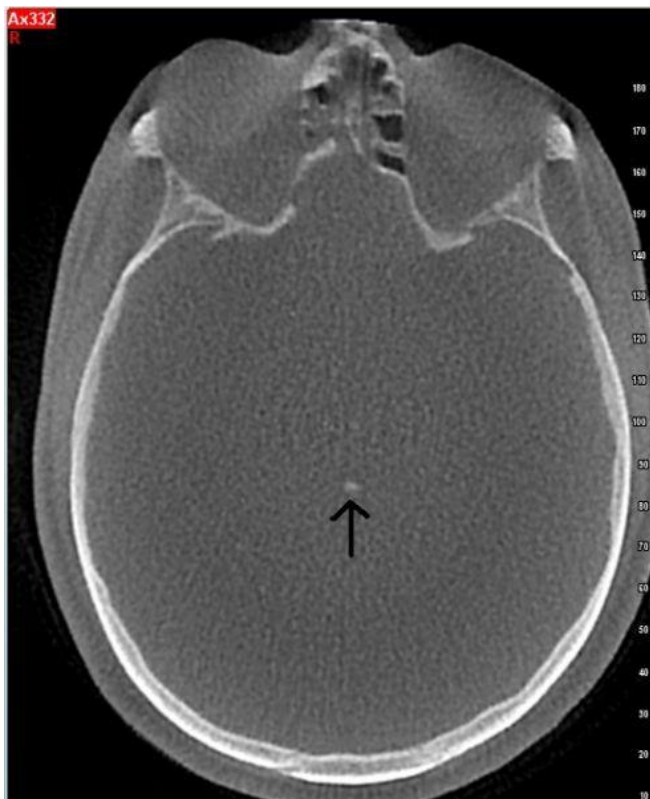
Axial cone beam computed tomography images of habenular calcification (black arrow)
